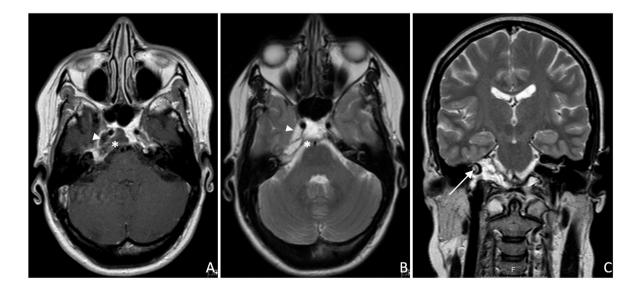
Axial (A) T1 post-gadolinium and (B) T2-weighted magnetic resonance. Post-radiotherapy MRI shows substantial lesion regression, with substitution of the isointense signal by a space related to a cystic tumorous cavity filled with liquid with hyposignal on T1 and hypersignal on T2 (*). Note the remodelling decrease of the right temporal lobe. The cistern of Gasser's ganglion (white arrow) is only seen in the post-radiotherapy MRI, because previously it was compressed just like the otic capsule (long white arrow) seen on (C) coronal T2-weighted magnetic resonance.
